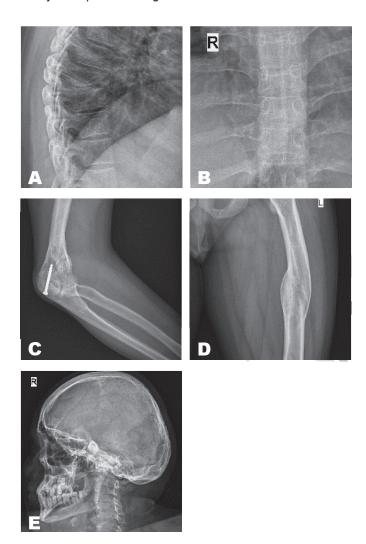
(A) Anteroposterior radiograph from dorsal spine shows anterior Wedge fracture in T7 and spinal mal alignment in the form of Kyphoscoliosis. Diffused reduction in spinal density due to Osteoporosis is seen, (B) Lateral radiograph from dorsal spine shows anterior Wedge fracture in T7 and spinal mal alignment in the form of Kyphoscoliosis. Diffused reduction in spinal density due to Osteoporosis is seen, (C) Elbow joint radiograph shows severe decrease in joint space (fusion article), flexion deformity and malunion due to fracture following previous trauma suggestive of severe secondary Osteoarthritis. Bowing deformity of Radius is seen. Relative reduction in bones' cortical thickness is suggestive of Osteoporosis. Metal fixator is observed in the distal of Humorous, (D) Anteroposterior radiographs from left Femur bone shows malunion of Femoral shaft following previous fracture along with Bowing deformity of Femur. Relative reduction in bone's cortical thickness is suggestive of Osteoporosis, and (E) Lateral radiograph from skull shows small bones with irregular border among Parietal and Occipital bones (Lambdoid suture) suggestive of Wormian bones.
